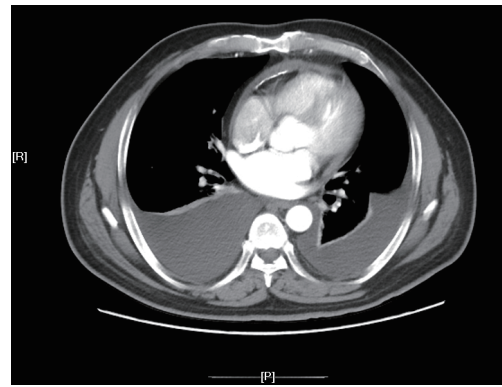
Chest CT image of the cross view which show the calcified pericardial wall.
